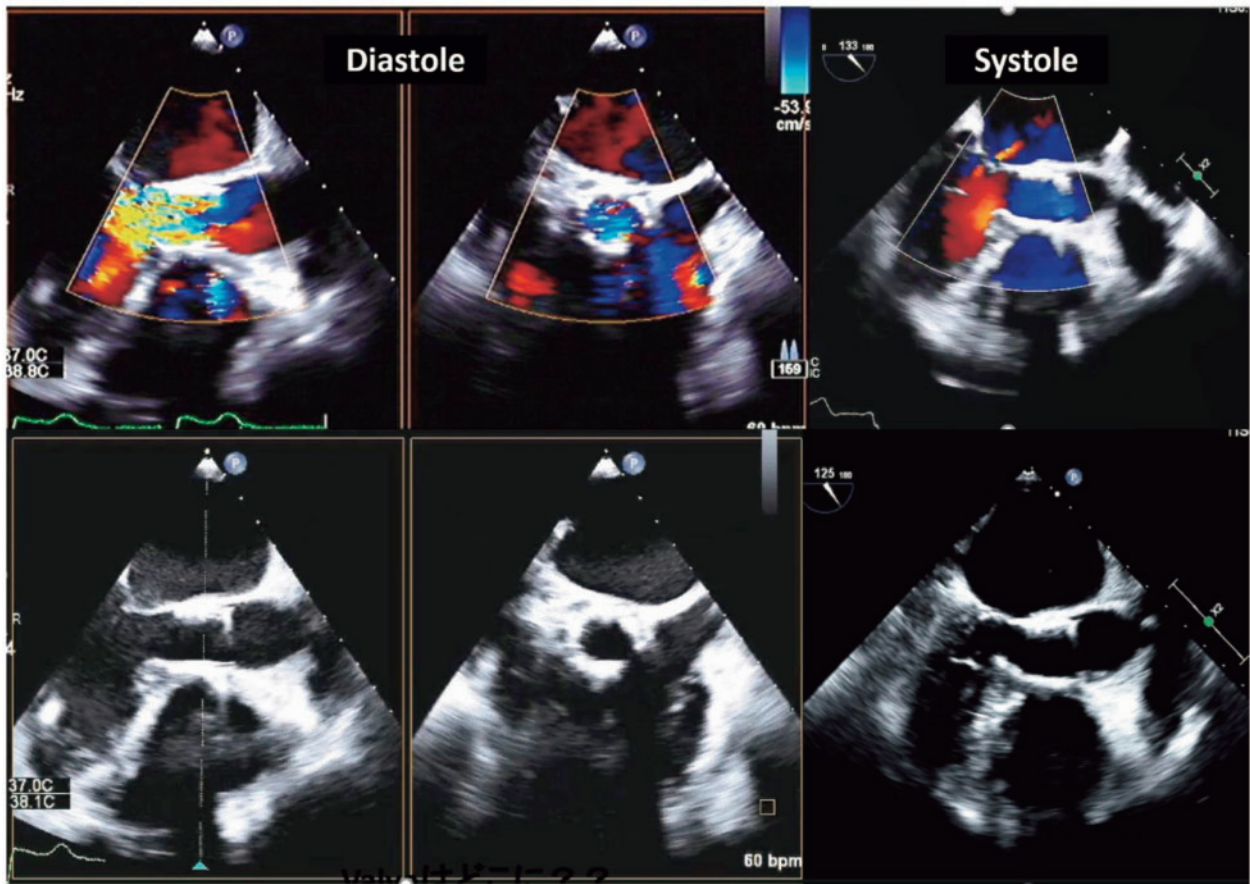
(A) The delivery balloon slipped into the left ventricle and the valve top was not fully expanded. (B) Transoesophageal echocardiography showing a mild paravalvular leak and insufficient valve top expansion.
